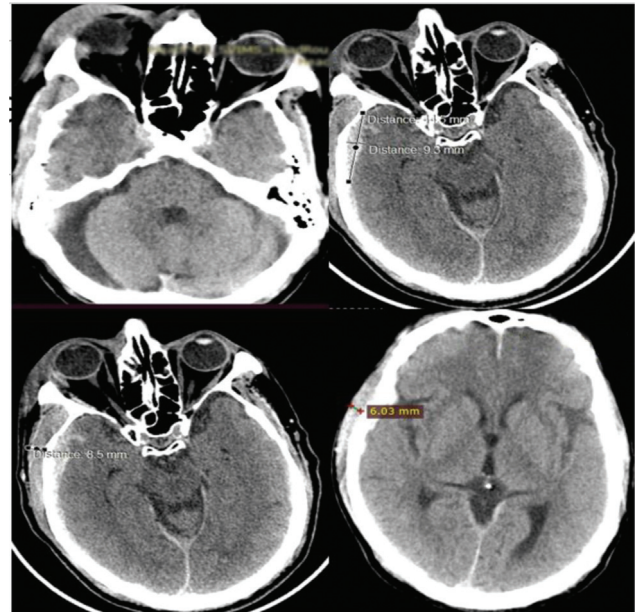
Computed tomography scan done after 5 hours of trauma.
